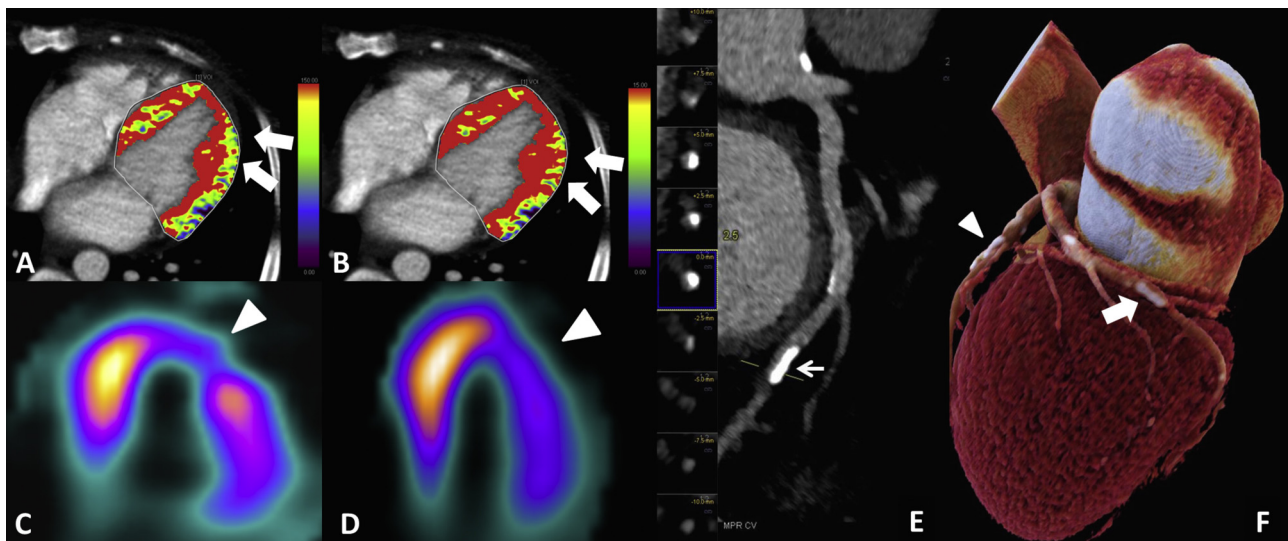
59 year old female patient complaining of chest pain episodes lasting up to 30 min and radiating to left shoulder. The Dynamic CT MPI with a color coded map of myocardial blood flow (A) shows a decreased blood flow in the anterolateral wall of the left ventricle (white arrows). The Dynamic CT MPI with a color coded map of myocardial blood volume (B) shows a decreased volume in the anterolateral wall of the left ventricle (white arrows). SPECT imaging of the heart in rest (C) and stress (D) phases shows a fixed perfusion defect in the anterolateral wall region, involving approximately 20–25% of the LV myocardium (white arrowheads). Dynamic CT MPI gives the ability to generate time attenuation curves of the myocardium (E).
